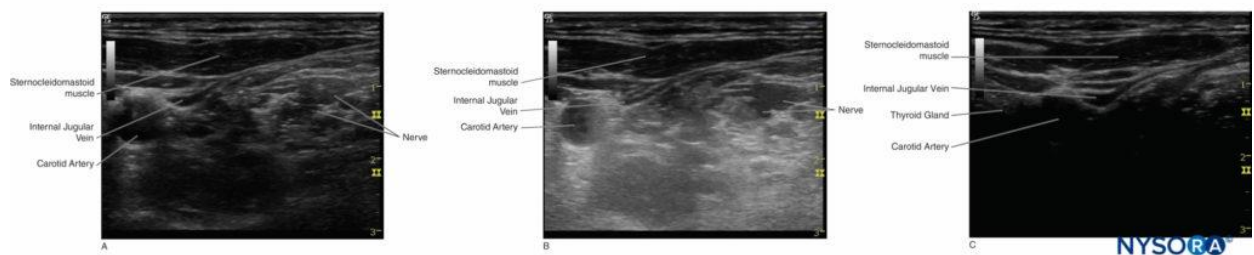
A, B, and C: The effect of the time-gain compensation settings. Time-gain compensation is a function that allows time- (depth) dependent amplification of signals returning from different depths. (Adapted with permission from Hadzic A: Hadzic's Peripheral Nerve Blocks and Anatomy for Ultrasound-Guided Regional Anesthesia, 2nd ed. New York: McGraw-Hill, Inc; 2011.)
